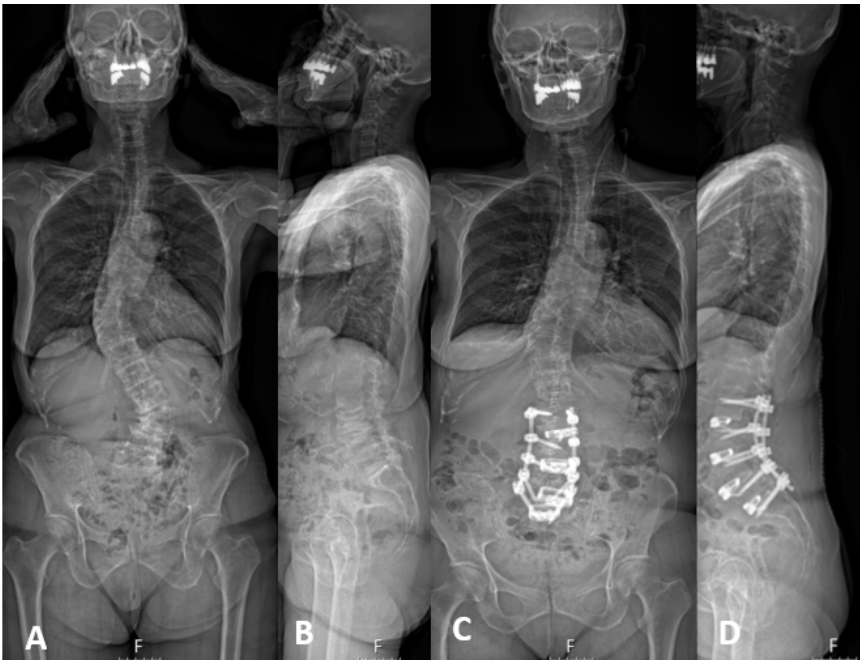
A. Pre and B. Post-operative Full standing spine X-Rays-EOS of a multilevel ALIF for treatment of adult deformity scoliosis.
